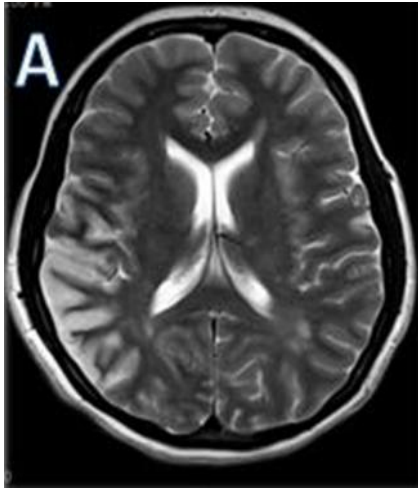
Brain MRI: T2 Axial Image Shows Multiple Deep White Matter, Abnormal High Signal Intensities Typical for MS along with Abnormal Right Parietal Gray Matter Signal Intensity
